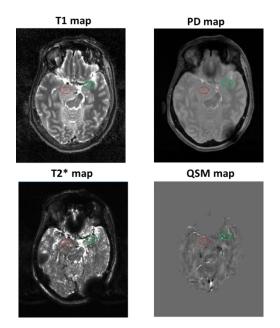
Example of the T1, T2*, PD and QSM maps derived from MTP MRI., Red ROI represents the malignant lesion and green ROI represents the healthy tissues
